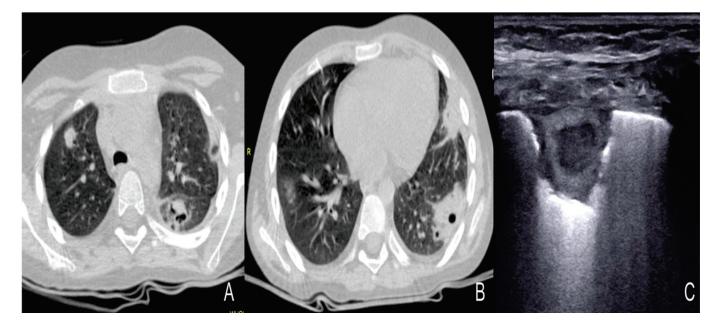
(A) Multiple nodular lesions with ground-glass opacity or halo sign, without air crescent sign. Two target lesions in ultrasound. (B) Hyper-echoic central nodule with a hypo-echoic rim. Figure (C) Hypo-echoic center with a hyper-echoic rim. (D,E) A nodular lesion of the right lung that has developed and air crescent sign in control HRCT [36].
